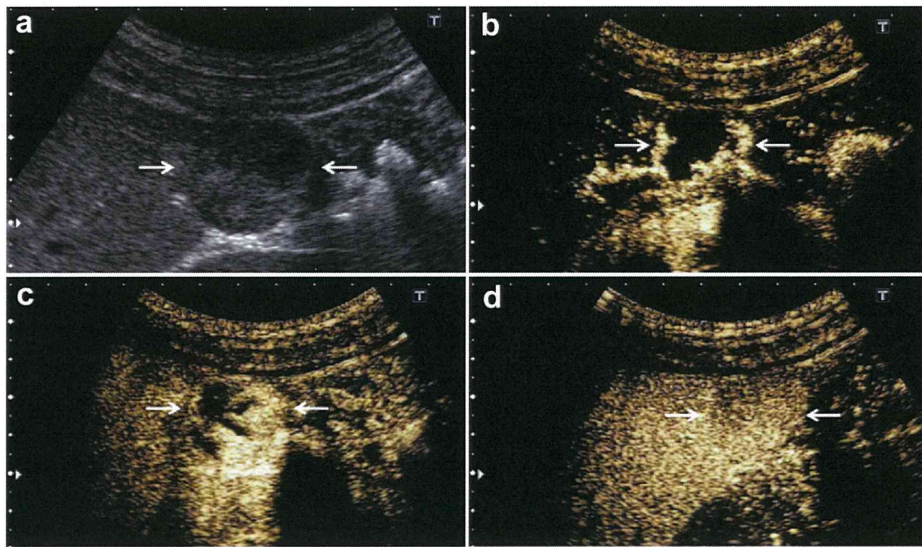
Forty-six-year-old woman with normal liver function and a typical hemangioma in segment 6. (a) B-mode ultrasound image reveals a mixed-echoic mass (lesion diameter = 20 mm) (arrows). (b) Vascular-phase image reveals fill-in enhancement of the peripheral portion of the lesion (arrows). (c) Late vascular-phase image reveals nearly complete centripetal progression of fill-in enhancement (arrows). (d) Kupffer-phase image (10 min after injection) reveals a nearly iso-echoic lesion compared with adjacent liver parenchyma (arrows).
